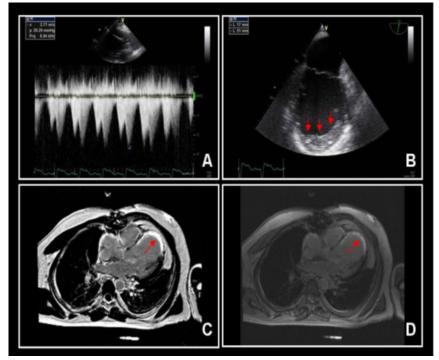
Three-dimensional echocardiography and cardiac-MRI demonstration.
